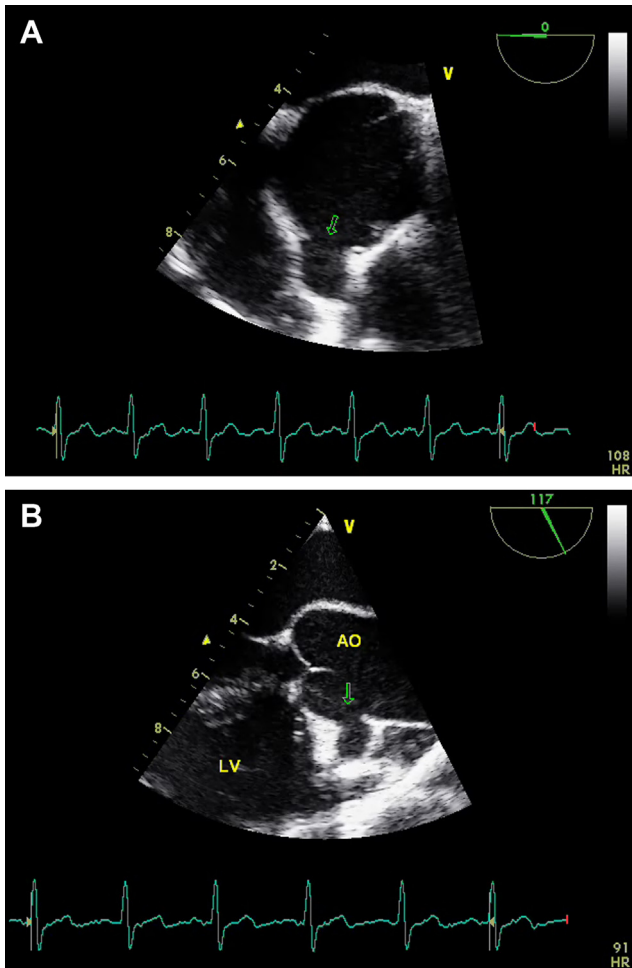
A: Transesophageal echocardiography in short axis showing ostial right coronary artery aneurysm (Arrow). B: Transesophageal echocardiography in long axis view showing ostial right coronary artery aneurysm (Arrow).
